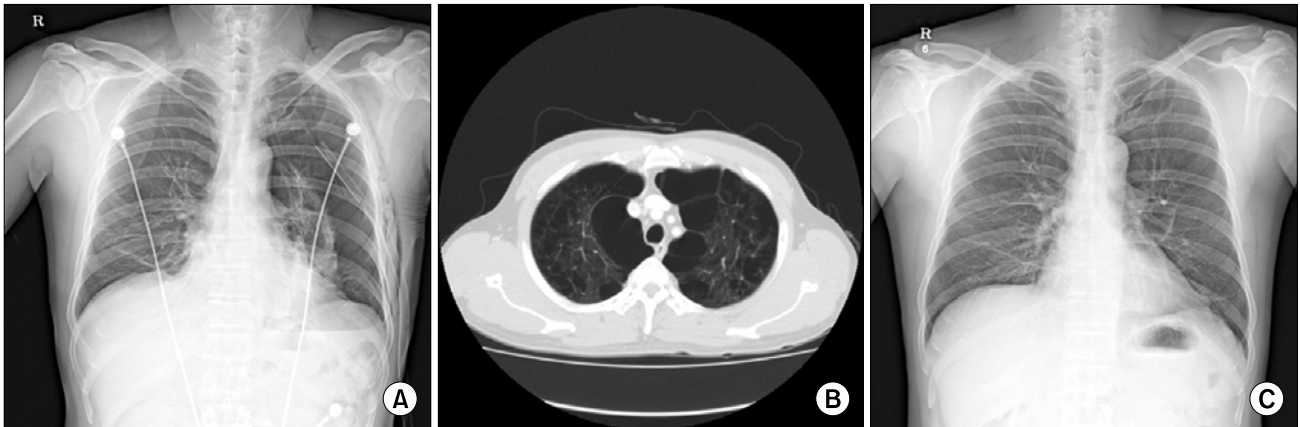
(A) Chest X-ray on admission demonstrated a left pneumothorax in spite of chest tube insertion. (B) Diffuse lung emphysema with multiple bullae in both upper lobes was seen on chest computed tomography on admission. (C) After insertion of the endobronchial Watanabe spigot, air leakage stopped and the pneumothorax improved.
